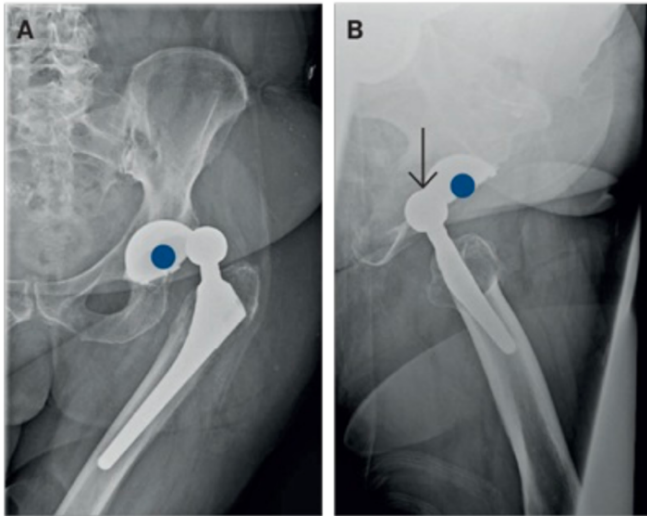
Radiographic image of a posterior dislocation after (THA) in anterior- posterior view; the center of the cup is marked with a blue dot.
